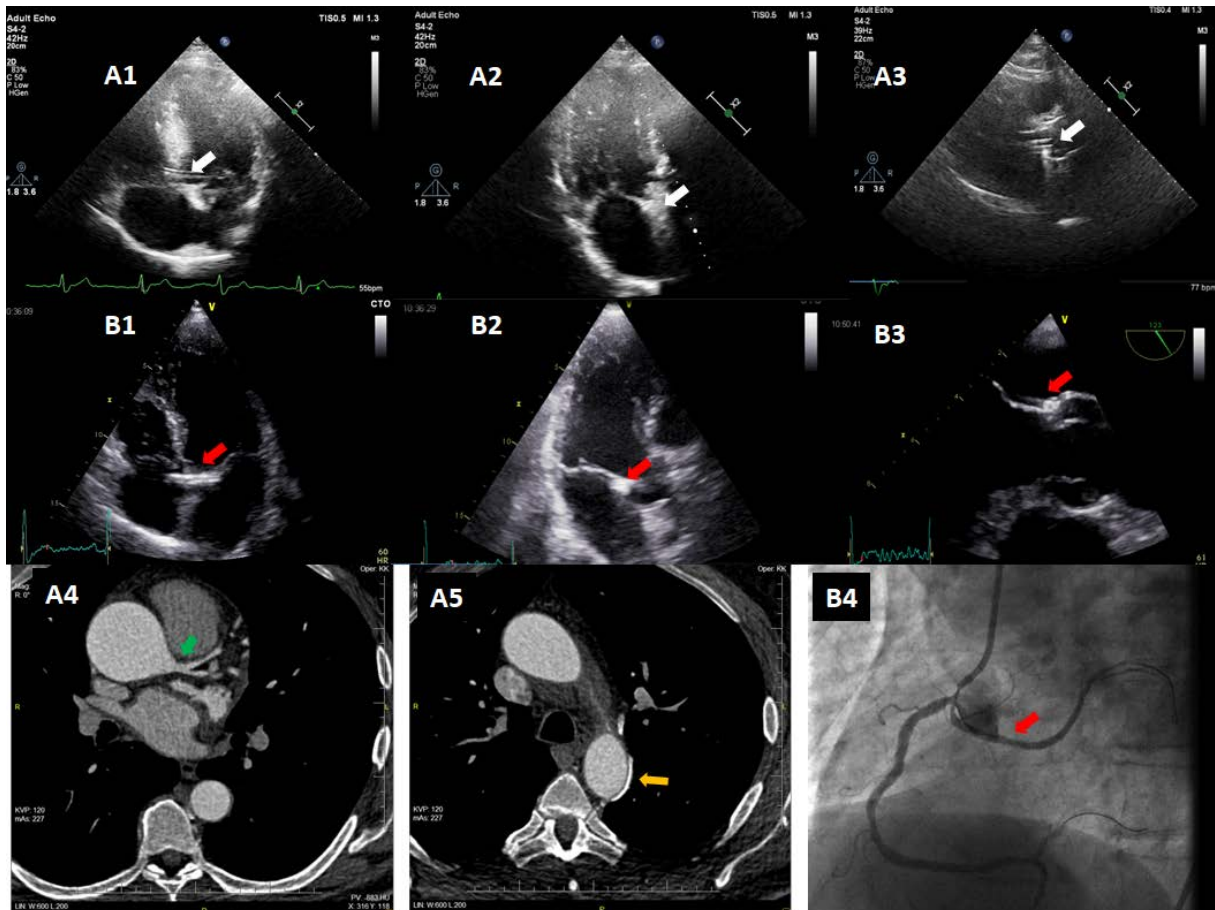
The apposition of the images in patient with the mechanical bileaflet aortic valve presenting “crossed aorta” sign despite normal anatomy of origin and proximal course of left CA (images denotes with A letter) with the images of other patient with anomalous origin of the circumflex CA from right coronary artery forming true positive for retroaortic course of CA “crossed aorta” or RAC sign as well as “bleb sign” in transesophageal study (images denoted by B letter). A1–A3. False-positive or pseudo crossed aorta sign. A1. Crossed aorta sign (white arrow) in apical view. A2. Echo shadow originated from the posterior aortic valve disc obliterates the retroaortic region at the base of mitral leaflet when the presence of “bleb sign” should be assessed (white arrow). A3. The opened mechanical aortic discs form parallel lines inside aortic lumen in long axis parasternal view during systole (white arrow). B1–B3. Special version of true positive crossed aorta sign (with coronary stent inside). B1. Crossed aorta sign (red arrow) in apical view, image is formed by retroaortic course of circumflex CA which additionally has a stent implanted in its proximal part enhancing the image of the vessel wall (B2) the cross-section of the stented retroaortic circumflex artery is visible as hyperechogenic speckle in the mitroaortic angle (red arrow) (B3) the same region examined
